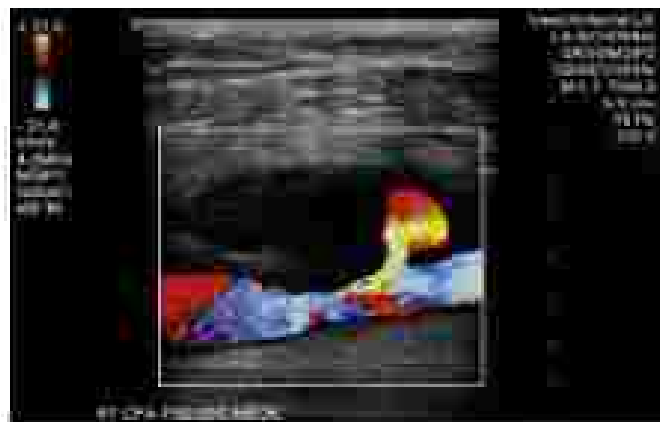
Duplex ultrasound image of a pseudoaneurysm located a half-circumference adjacent to the femoral artery. A high-velocity jet through the arterial wall and a neck of communication with the artery.
